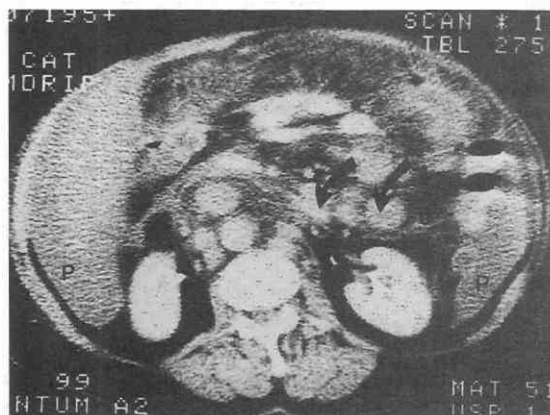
CT scan of a patient with intra-abdominal tuberculosis. There is fluid in the pericolic spaces (p) and large lymph nodes (arrows) in the retroperitoneum and mesentery.
